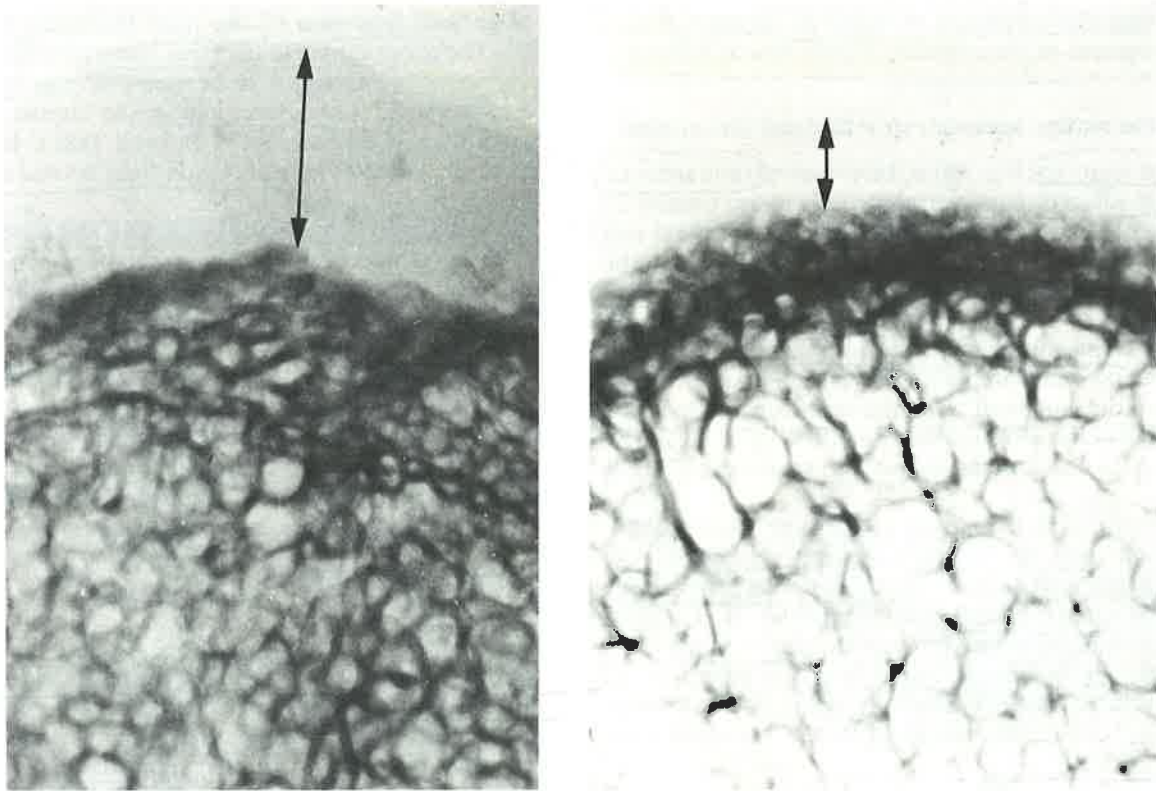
Microfocal radiographs of the rims of the bodies of the fifth lumbar vertebra in 40-year-old male subjects. *Right*, normal control demonstrating a normal trabecular pattern with thickened cortical bone and thin overlying prevertebral tissue (arrow). *Left*, segment of bone removed at the time of anterior lumbar fusion when marked prevertebral inflammatory reaction and oedema was observed. Note the thickening of the prevertebral tissues (arrow) which was due to infiltration with chronic inflammatory cells. (Microfocals courtesy of Dr W.M. Park.)
